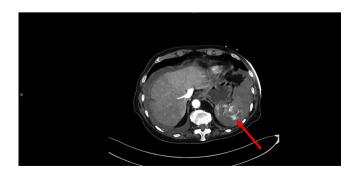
Transverse section of contrast-enhanced CT abdomen showing free fluid (blood) and laceration of spleen (red arrow).
